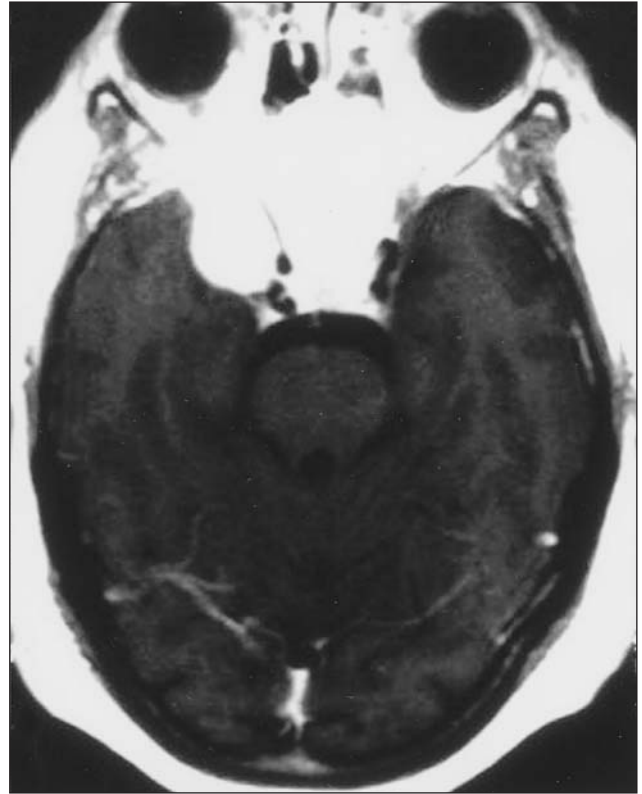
The axial T1-weighted MRI scan of the patient showing the contrast enhancing mass lesion in the sella turcica and right temporal lobe.
